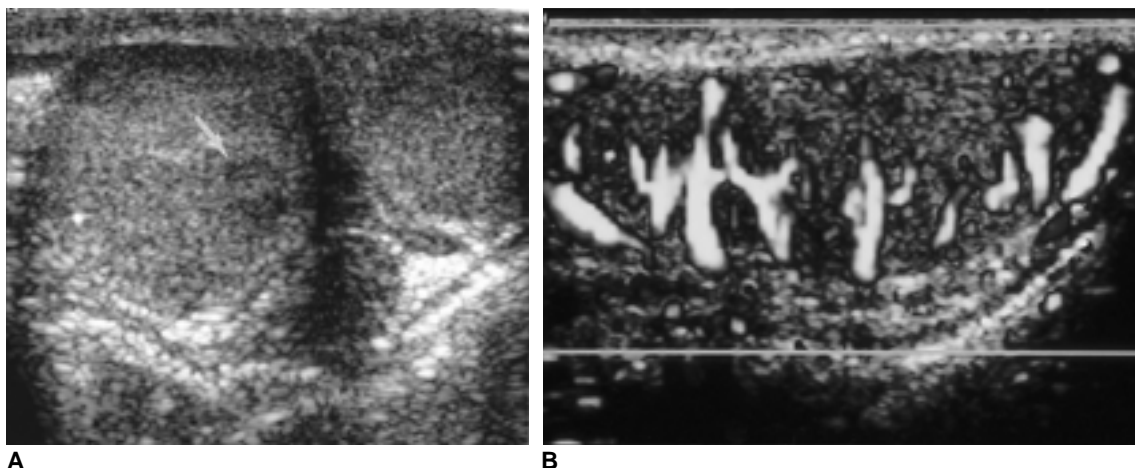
A 14-year-old boy with a history of ALL. A. Transverse gray-scale US on both testes shows the enlarged right testis with a 1 cm-sized discrete single isoechoic nodule (arrow) in the background of homogeneous isoechogenicity compared with the normal left testis. B. Longitudinal power Doppler image of the involved right testis shows diffuse and marked hypervascularity throughout the testis.
